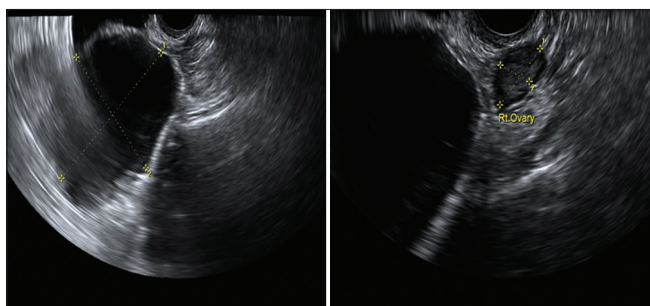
Ultrasound showing a large anechoic cyst with adjacent normal right ovary
